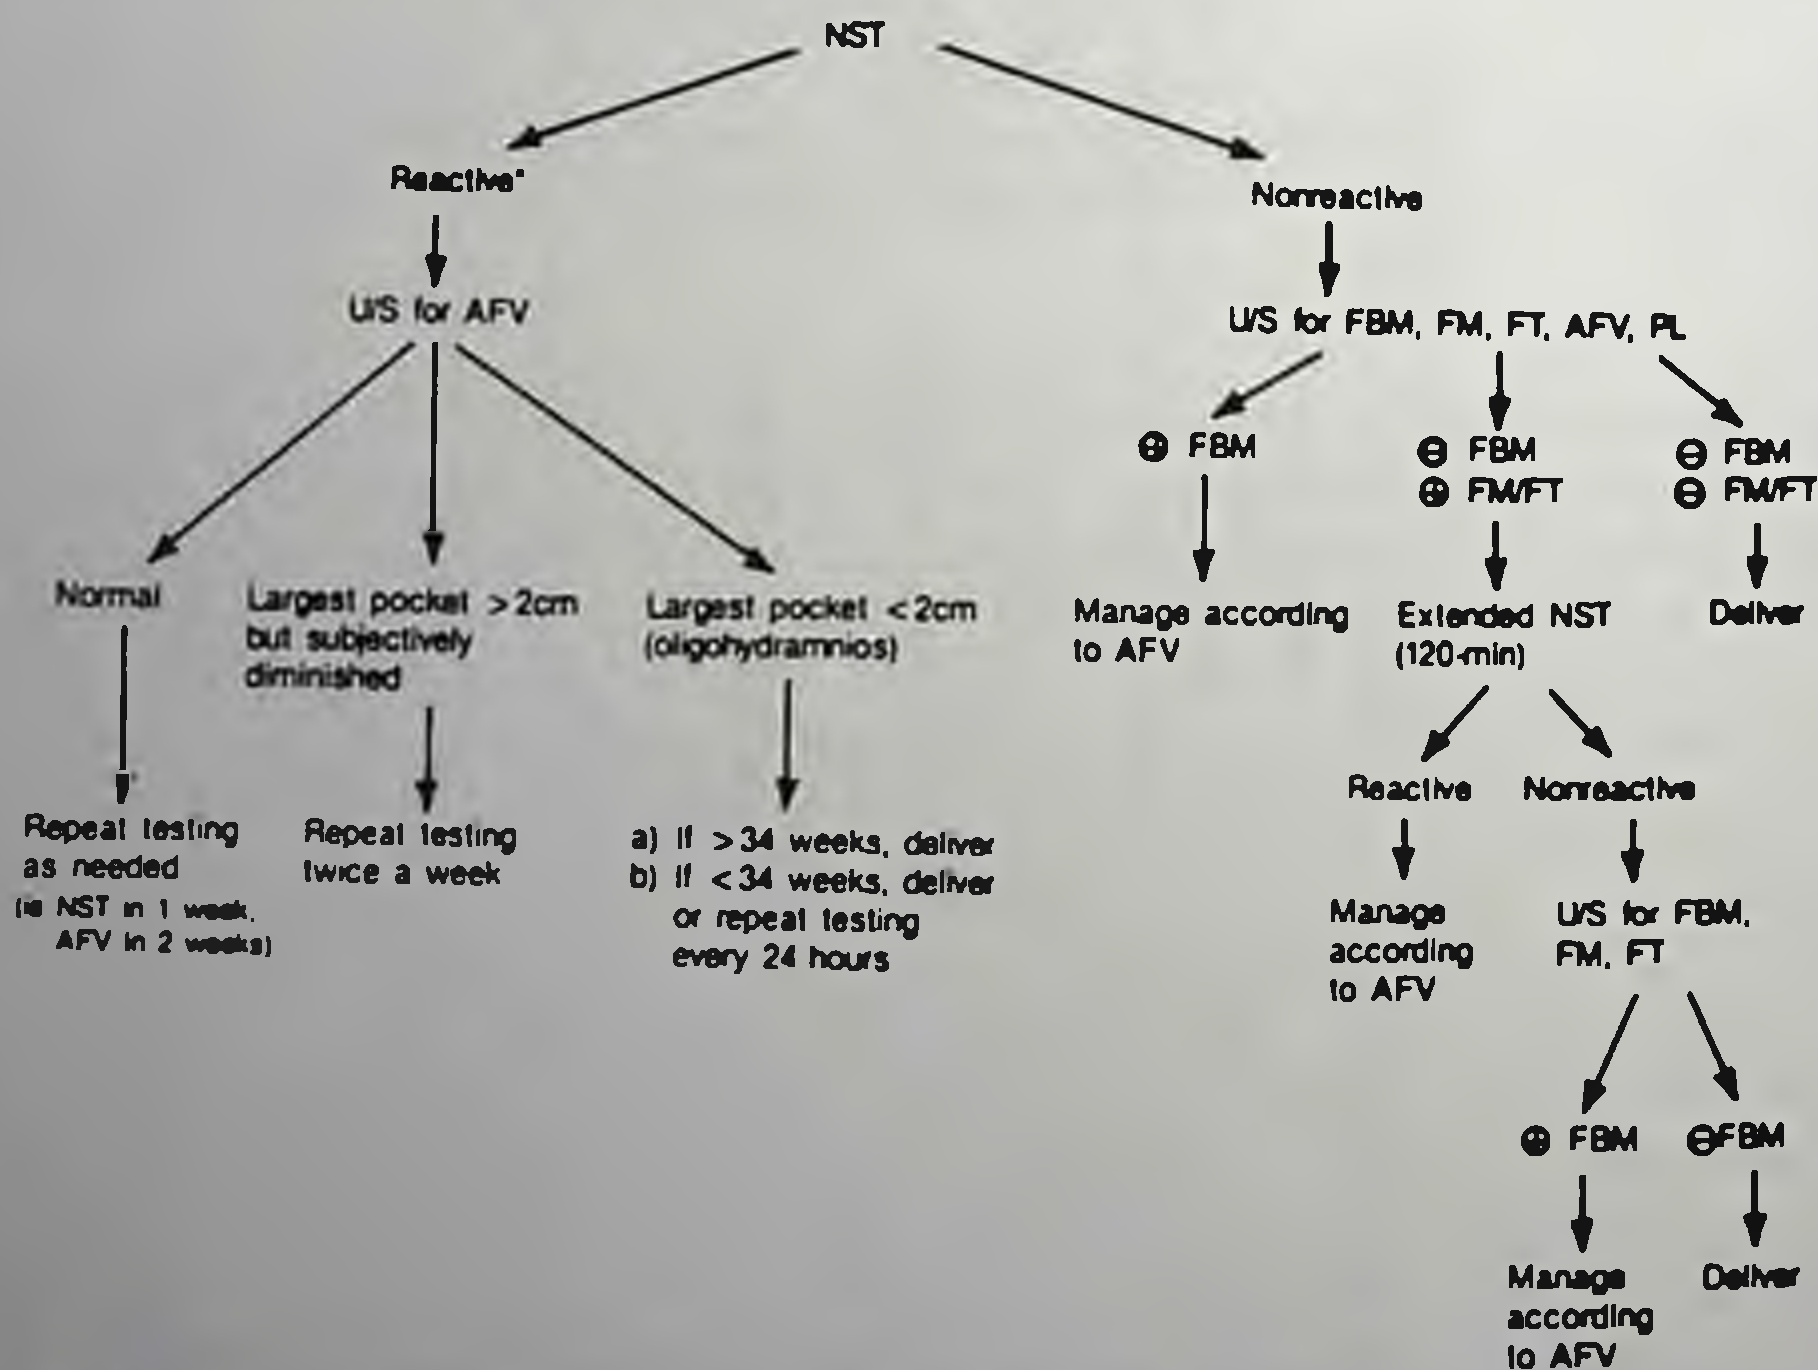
Protocol of antepartum fetal evaluation in pregnancies with intact membranes. * In the presence of variable decelerations and oligohydramnios, consider delivery; in the presence of variable decelerations and normal AFV, consider extended (120 minutes) or repeat NST within 24 hours. Key. NST = Nonstress test; U/S = ultrasound; AFV = amniotic fluid volume; FBM = fetal breathing; FM = fetal movement; FT = fetal tone; PL = placental grading, + = present/normal; - = absent/abnormal. (Reprinted with permission from Am J Obstet Gynecol 157:627-631, 1987.)
